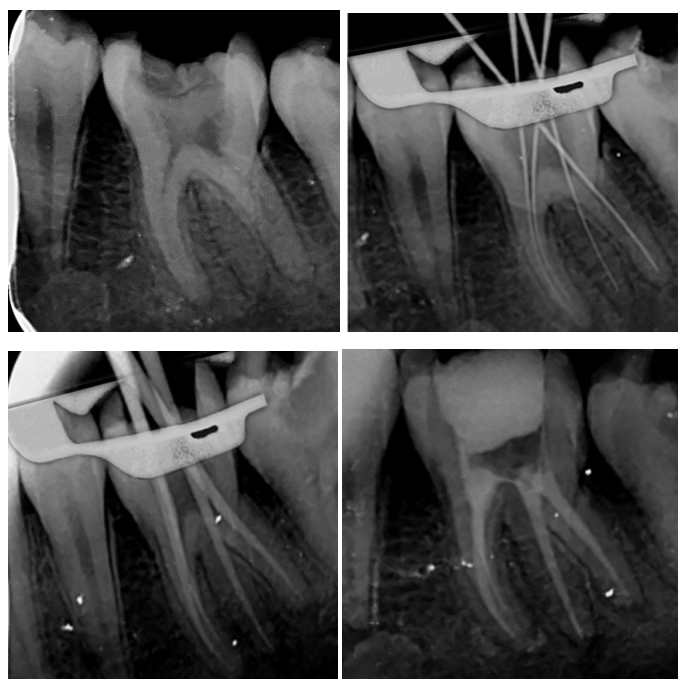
(a) Pre-op IOPA x-ray. (b) Working length Determination, (c) Master Cone. (d) Obturation
